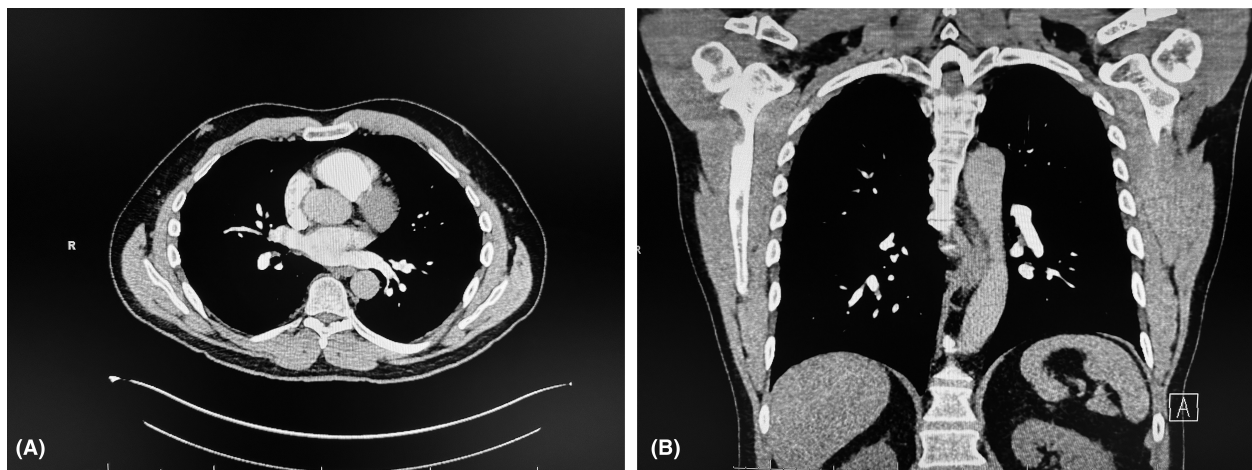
(A) Axial and (B) coronal repeat CT pulmonary angiogram demonstrated the resolution of clot. Obtained June 2023.
